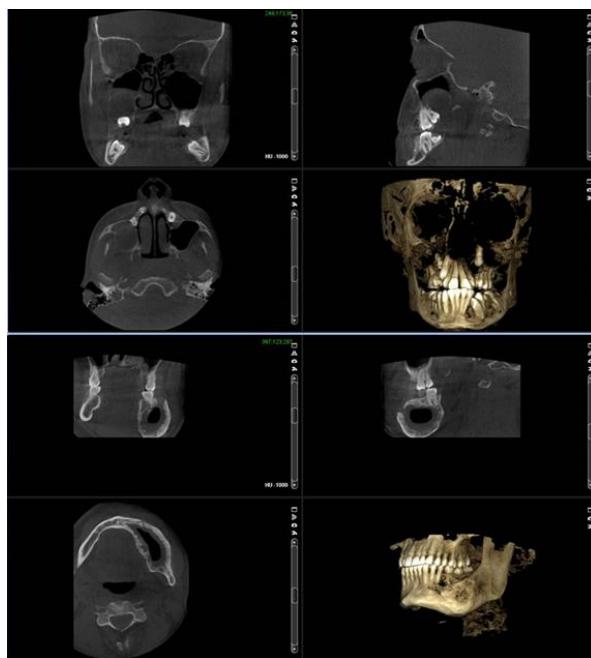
CBCT which was taken at the same time control panoramic film. (Patients 1 and 2)
